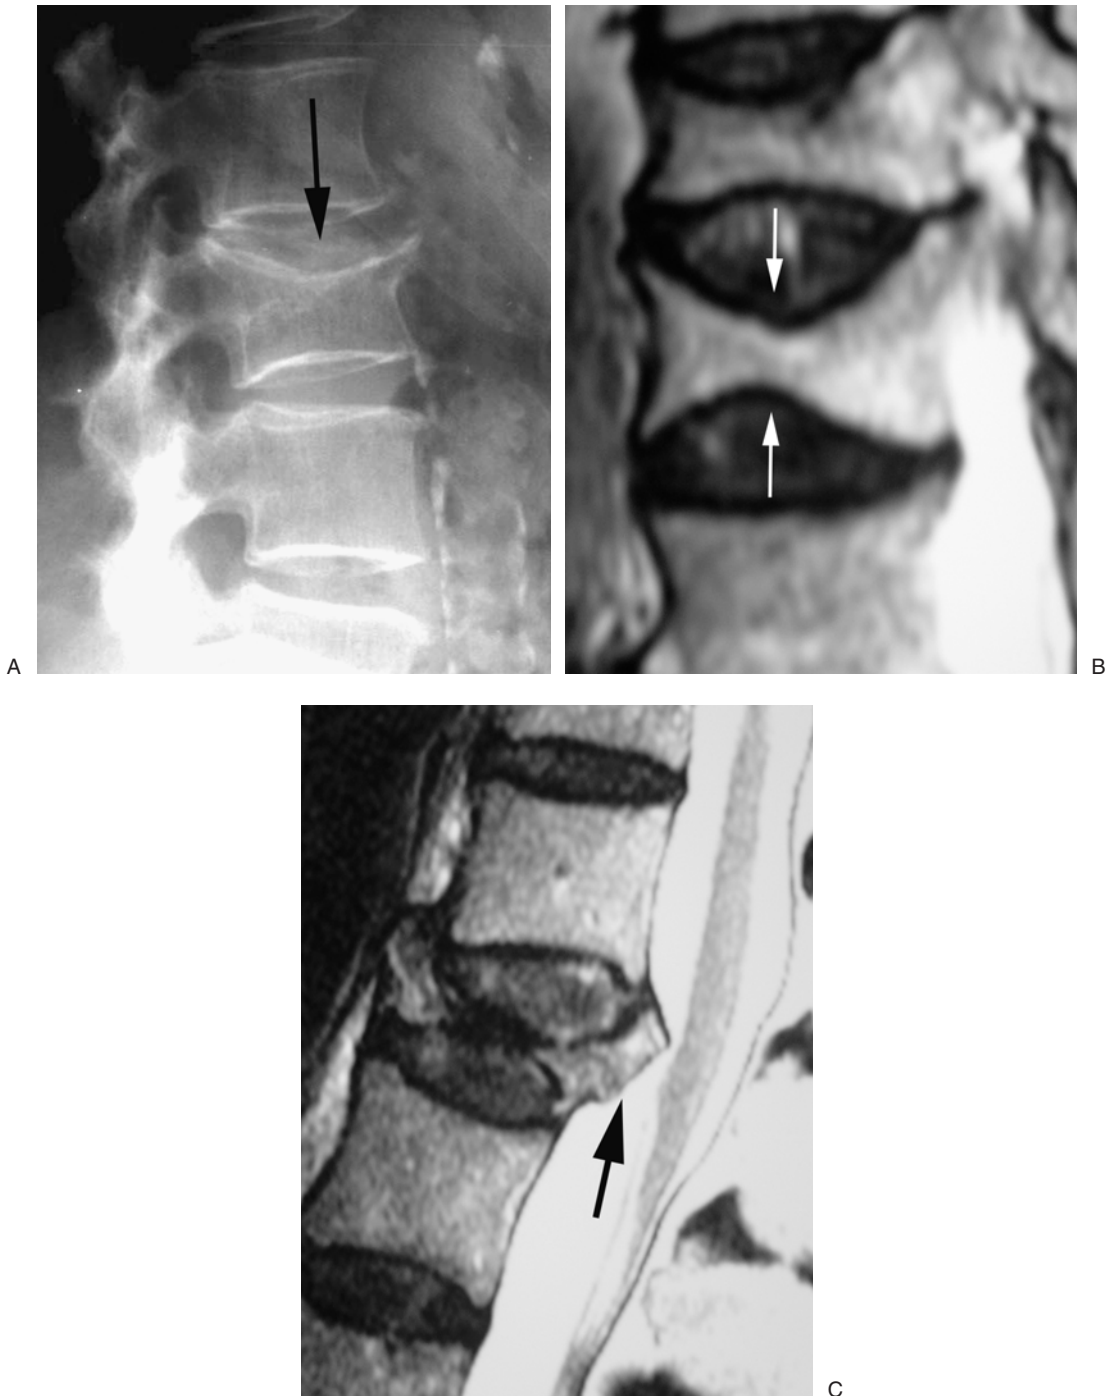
(A) Radiograph shows a simple compression fracture. The superior endplate is collapsed (black arrow), with most of the height loss in the anterior vertebrae and general sparing of the posterior wall. (B) Sagittal MRI shows a compression fracture with both endplate regions affected (white arrows). (C) Sagittal MRI shows marked collapse and buckling of the posterior wall (black arrow). There is mild encroachment on the spinal canal. In this patient there were no symptoms of cord compression and no contraindication to PV based on the canal encroachment.
